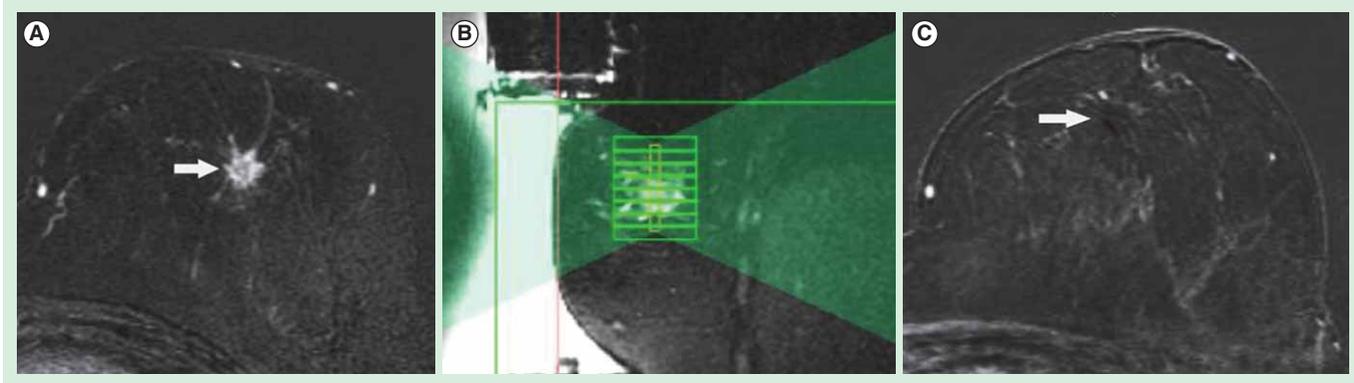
MRgFUS of breast invasive ductal carcinoma. (A) Subtracted 3D gradient echo T1-weighted axial image acquired after gadolinium injection shows a small rounded nodule of invasive ductal carcinoma between the upper quadrants of the left breast (arrow). (B) T1-weighted sequence acquired on a sagittal plane shows the predicted ultrasound beam path (green triangles) with the planned sonications (green boxes). (C) The same sequence acquired after magnetic resonance-guided focused ultrasound treatment shows the ablated area, without residual cancer enhancement (arrow).
